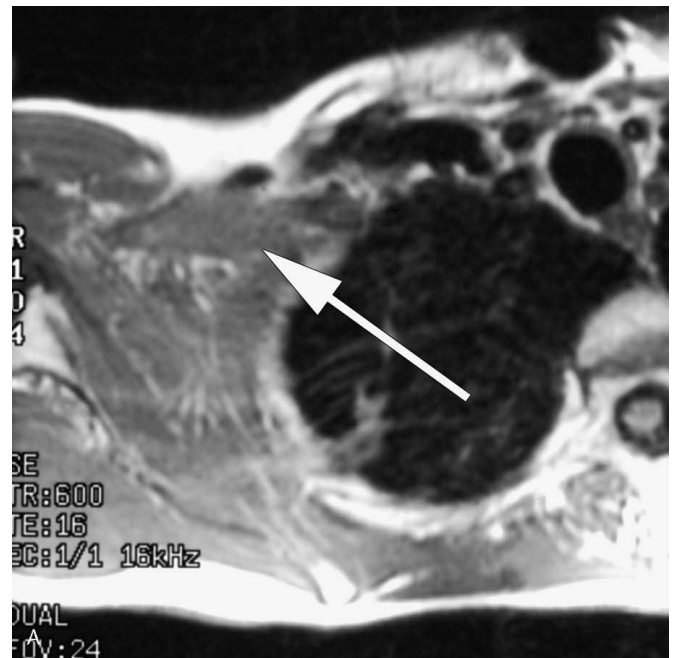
Post radiation Fibrosis. A, Axial T1-weighted image shows an irregular area isointense to muscles. B, Axial post-contrast T1-weighted image shows intense enhancement of the area revealing thickened divisions of the brachial plexus without evidence for a focal mass. (Courtesy of Douglas Quint, M.D., University of Michigan, Ann Arbor).
